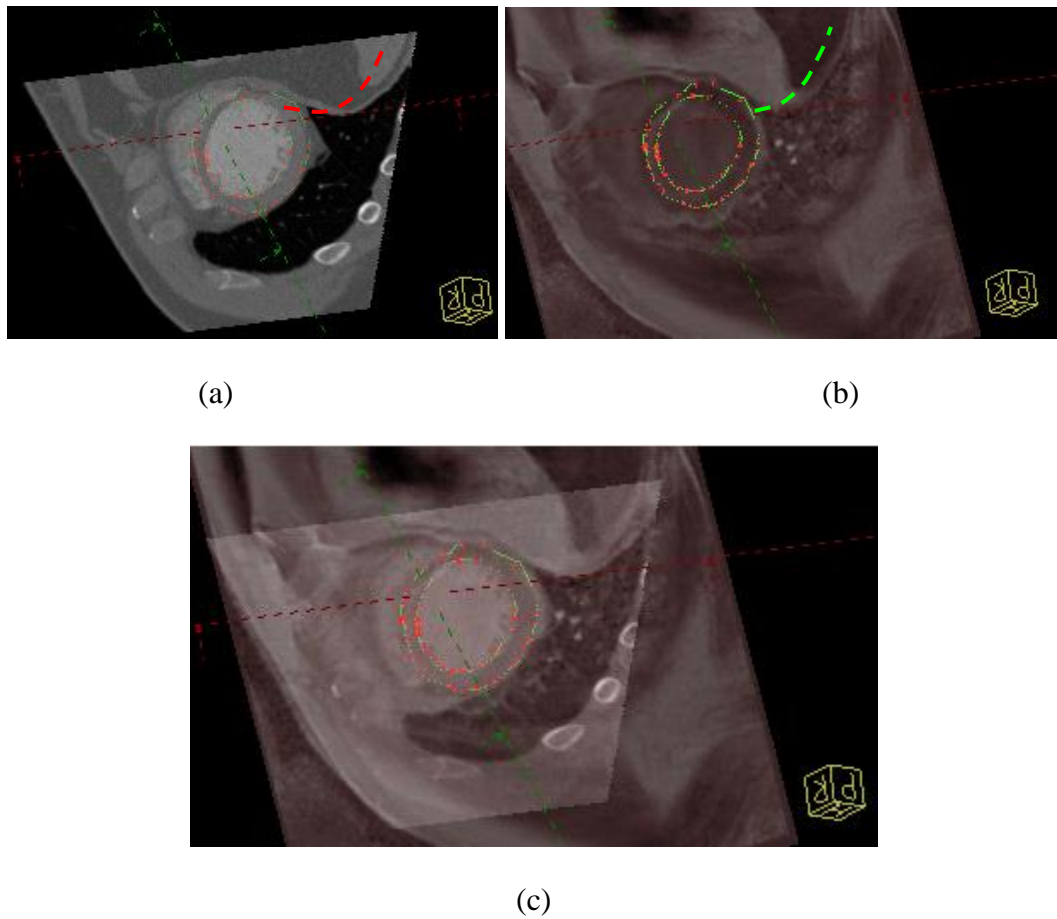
Final registration result for Patient 6; CTA (a), DEMR (b) and overlay of both images in the short axis view (c). Dashed lines in (a) and (b) indicate the end of the lung region in CTA (dashed red line) and in DEMR (dashed green line) images.
